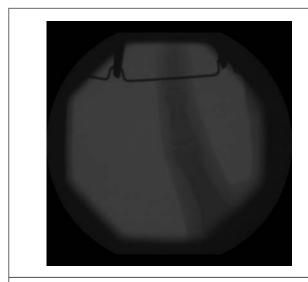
Pre-reduction x-ray
